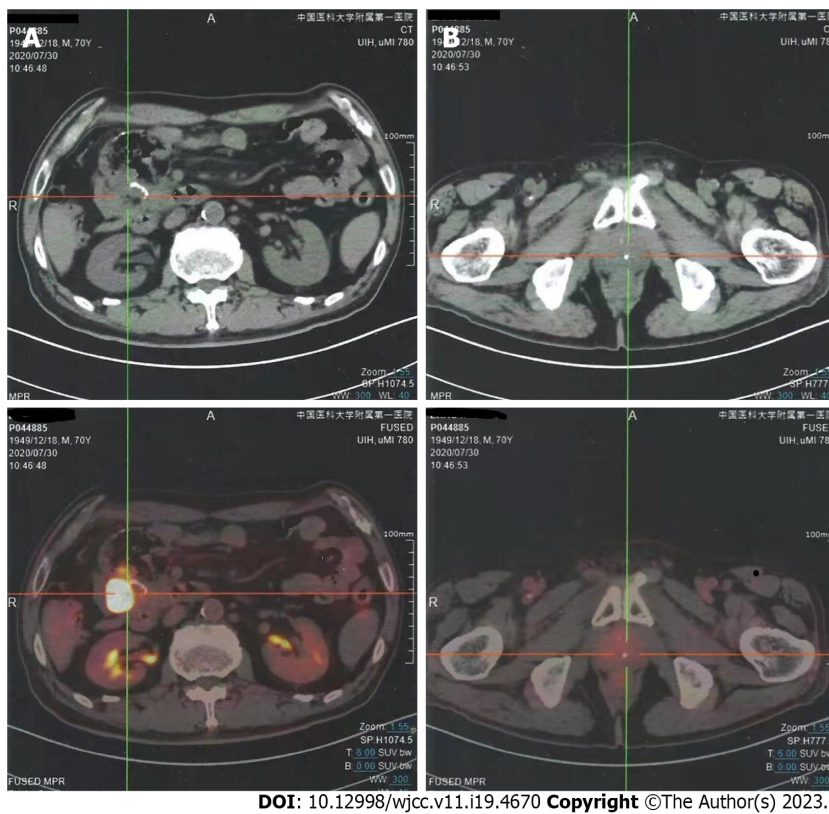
Computed tomography findings at postoperative day 37. A: Anastomosis recurrence; B: Pelvic metastasis.
